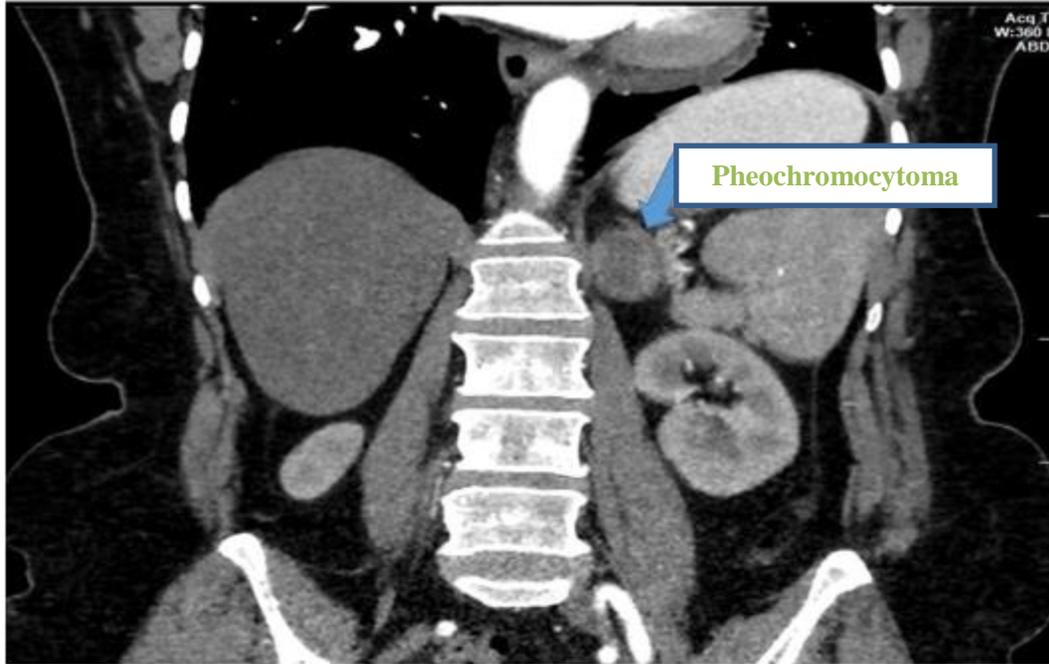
MRI of Pheochromocytoma
